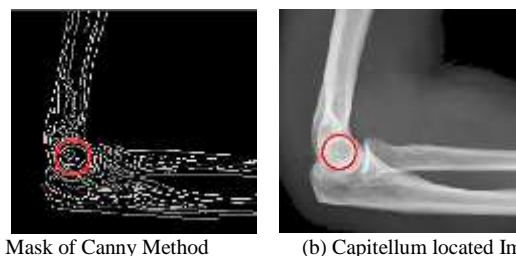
Capitellum Detection on the X-ray Image of Elbow. (a) Indicates the Circular Shaped Capitellum Detection on Canny Mask. (b) Indicates the Capitellum Visualization on Actual X-ray Image.
